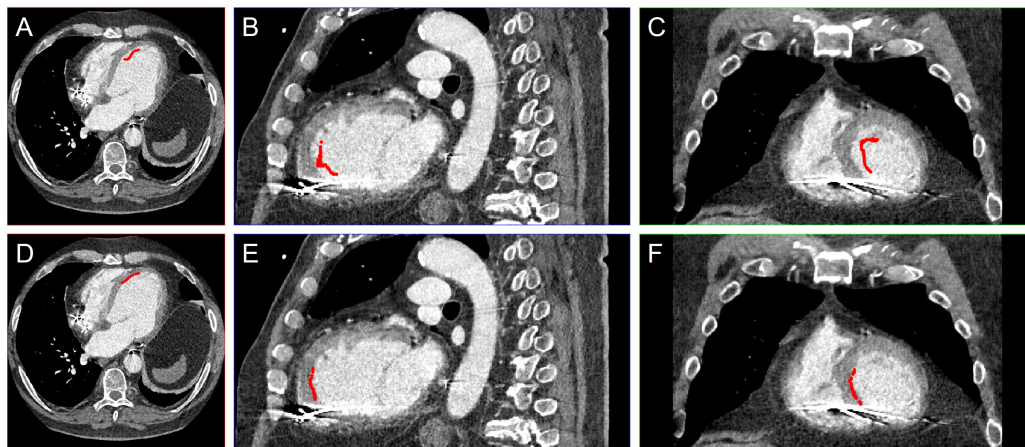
(A-C) The 3D-3D registered ventricular tachycardia (VT) target points (red) within the left ventricle (LV) blood pool, shown in axial, sagittal and coronal views of the cardiac computed tomography (CT). (D-F) The 3D-3D registered VT target points projected onto the LV point cloud (red), shown in axial, sagittal and coronal views of the cardiac CT.
